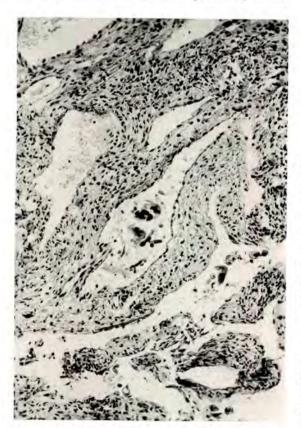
Lymphatic involvement. RST good. Cancer of the cervix, Stage ic. Treatment: Radium, external roentgen irradiation. Died of metastatic disease 1½ years later. H & E, ×207. There are tumor cells in a lymphatic of the cervix.
